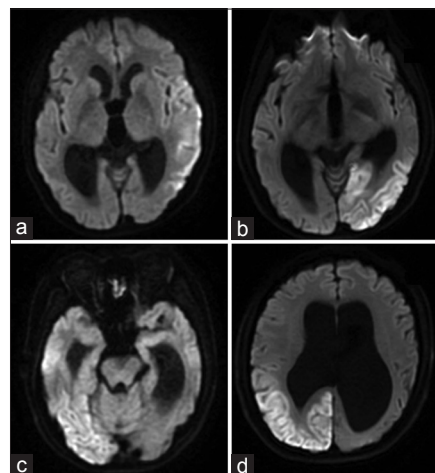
Magnetic resonance imaging results (diffusion weighted imaging) from the patient suffered four “stroke-like” accidents showing lesions at (a) left temporal lobe, (b) left temporal and occipital lobe, (c) right temporal lobe, (d) right parietal and occipital lobe.
